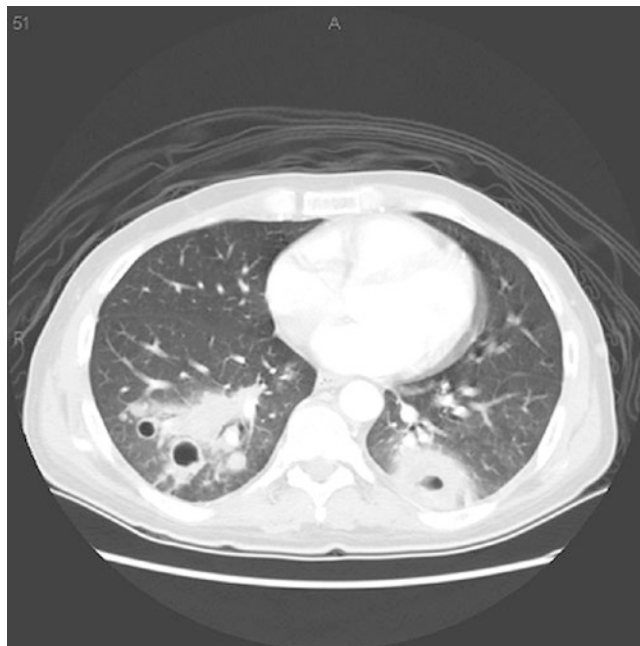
CT scan of lungs without intravenous contrast showing tree-in-bud appearance due to pulmonary *Mycobacterium avium* complex disease mostly involving the right lung demonstrating multiple areas of centrilobular nodules with a linear branching pattern. Endobronchial tuberculosis may present with such a radiographic finding, wherein patients with acutely developed tree-in-bud infiltrates bacterial or viral (CMV) etiology may also be entertained. It is important to note that bronchiectasis is the prominent radiographic presentation of *Mycobacterium avium* complex infection in patients undergoing transplantation. Rarely carcinomatous endarteritis due to breast or gastric cancer; bronchovascular interstitial infiltration due to lymphoma, leukemia, and sarcoidosis may have similar presentation. *Scedosporium* lung disease and pulmonary fusariosis may occasionally have nodular peribronchovascular distribution
